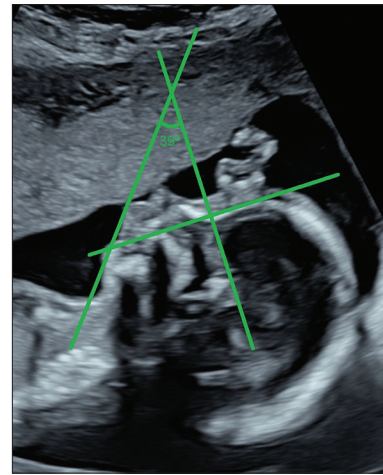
Mid-trimester ultrasound: inferior facial angle of 39° suggesting micrognathia
